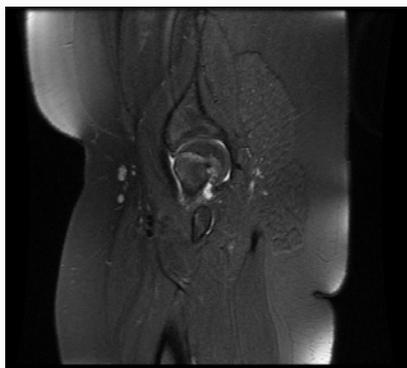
MRI sequence T2 of the left hip.
